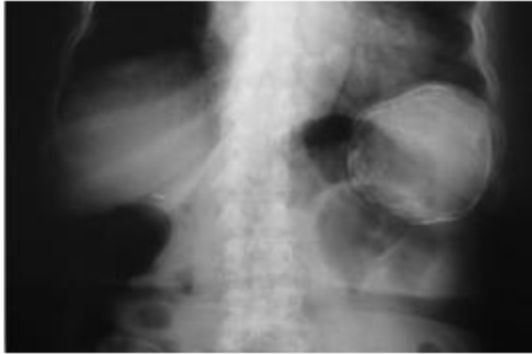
Plain x-ray of the abdomen revealing a well-defined rounded soft-tissue opacity with calcified margins in the left hypochondrium
